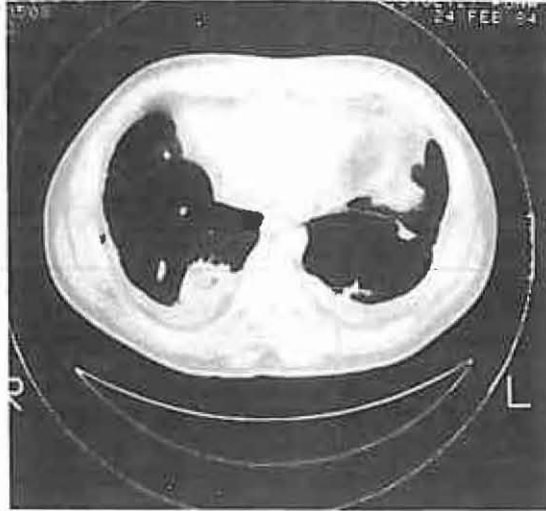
Chest CT of patient in Figure 24, showing right-sided posterior mass found at resection to be rounded atelectasis.
